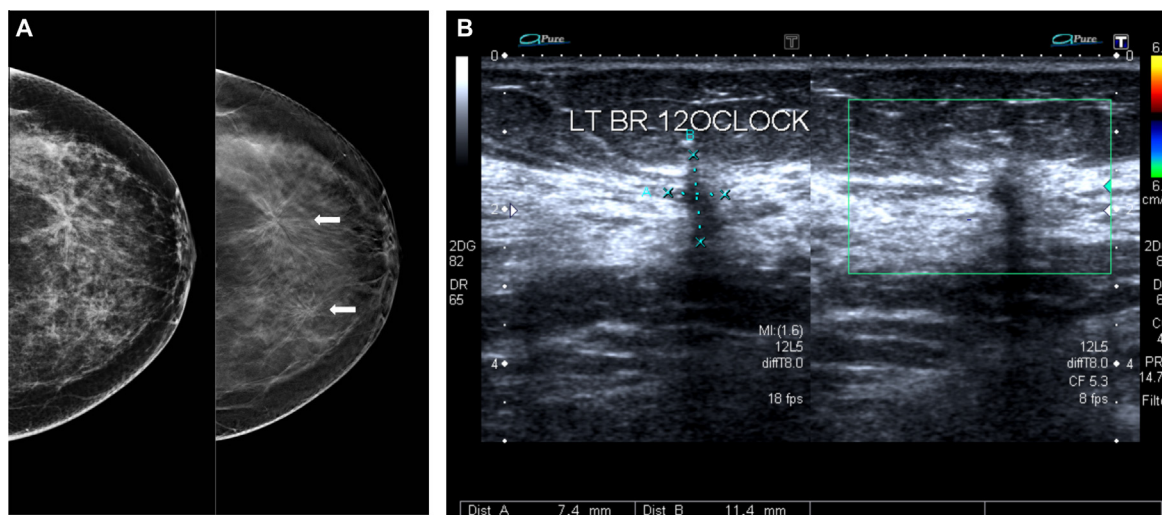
Screening mammogram showed a subtle mid upper breast area of parenchymal distortion that became more apparent on one of the tomosynthesis slices in addition to another lesion (arrows). Complementary ultrasound proved the presence of an underlying two tiny spiculated mass lesions.
